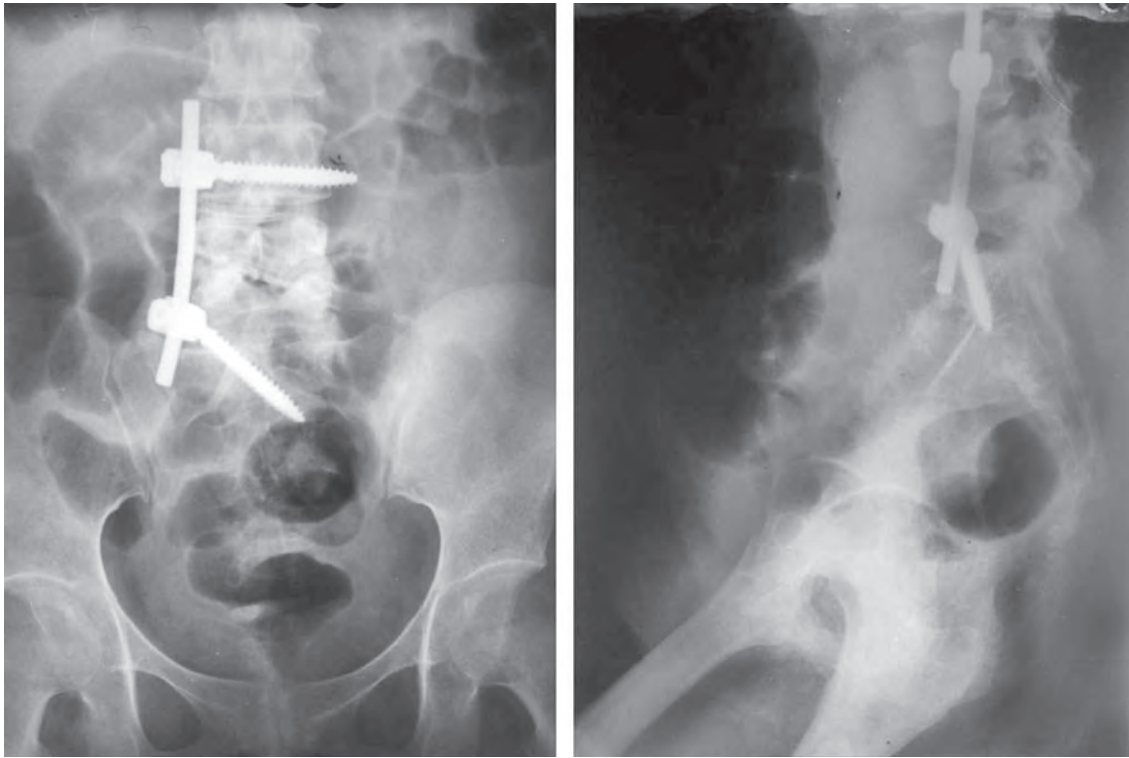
Post-operative X-rays showing spinal fixation
